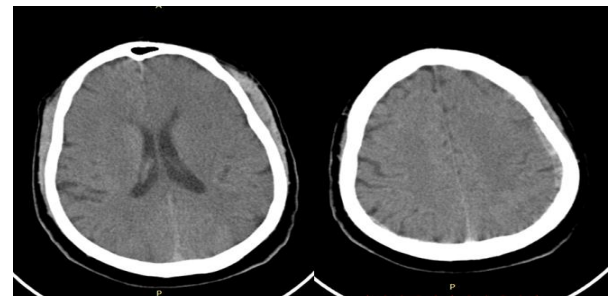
62-year-old man with COVID-19 presented with right hemiparesis and right facial nerve palsy and expressive aphasia. Head CT shows effacement
